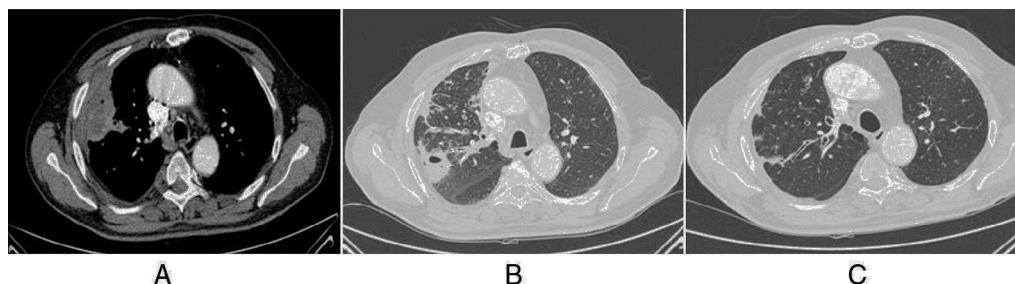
(A) Pulmonary mass in the peripheral right upper lobe (RUL) of necrotic and abscessed appearance, containing a small air bubble (mediastinal window CT image). (B) Previously described nodule has disappeared, and a new cavitated nodule has appeared close by. Bronchial wall thickening and RUL bronchial impaction (lung window CT image). (C) Resolution of previous findings (follow-up lung window CT image).
